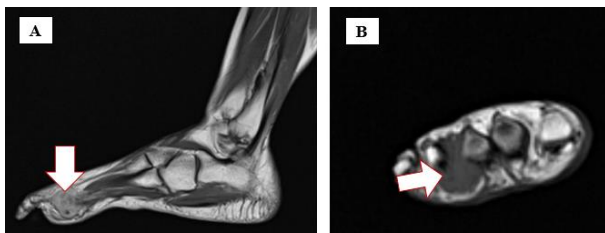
Magnetic resonance imaging of the foot in the sagittal (A) and coronal (B) planes. The arrow indicates the typical appearance of Morton's neuroma, particularly evident in image B, where it has a teardrop shape.
